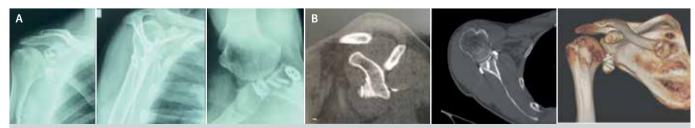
Complementary exams: X-rays and tomography. The patient has undergone previous Bankart repair surgery with metallic anchors.
